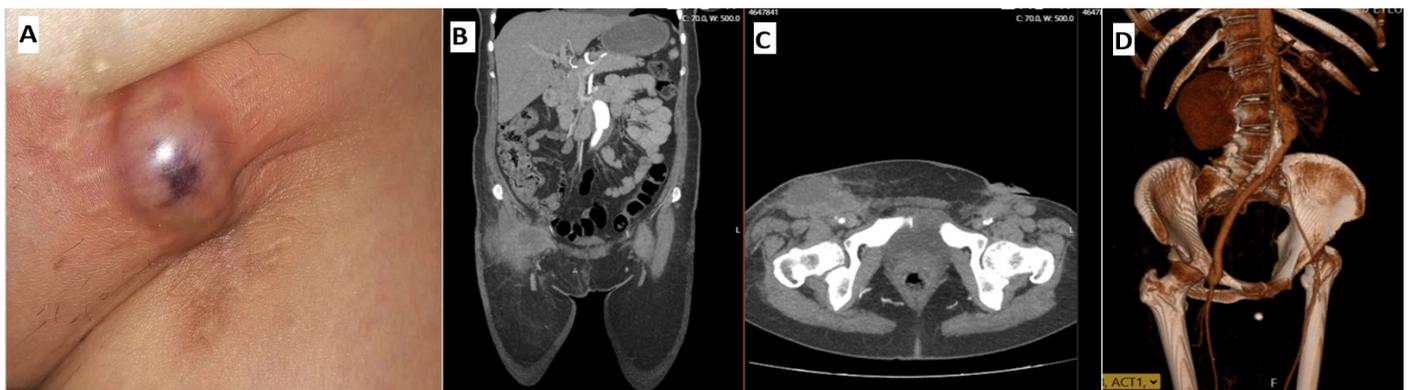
Preoperative findings of groin infection and perigraft inflammation. (A) Left groin clinical photograph showing a tense, erythematous swelling with violaceous discoloration at the prior incision line. (B) Coronal CTA demonstrating inflammatory changes around the aortobifemoral graft limbs. (C) Axial CTA at the pelvic level showing groin collections adjacent to the graft course. (D) 3D volume-rendered CTA depicting the aortic graft and iliac limbs with surrounding inflammatory reaction
